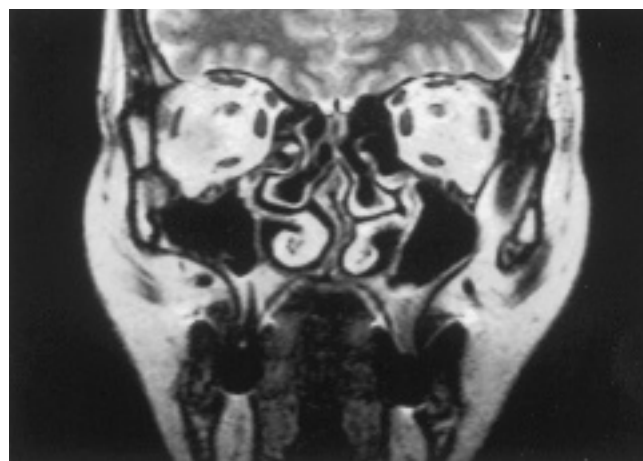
Coronal MRI scan showing massive bilateral middle concha bullosa and left sided septal deviation.
